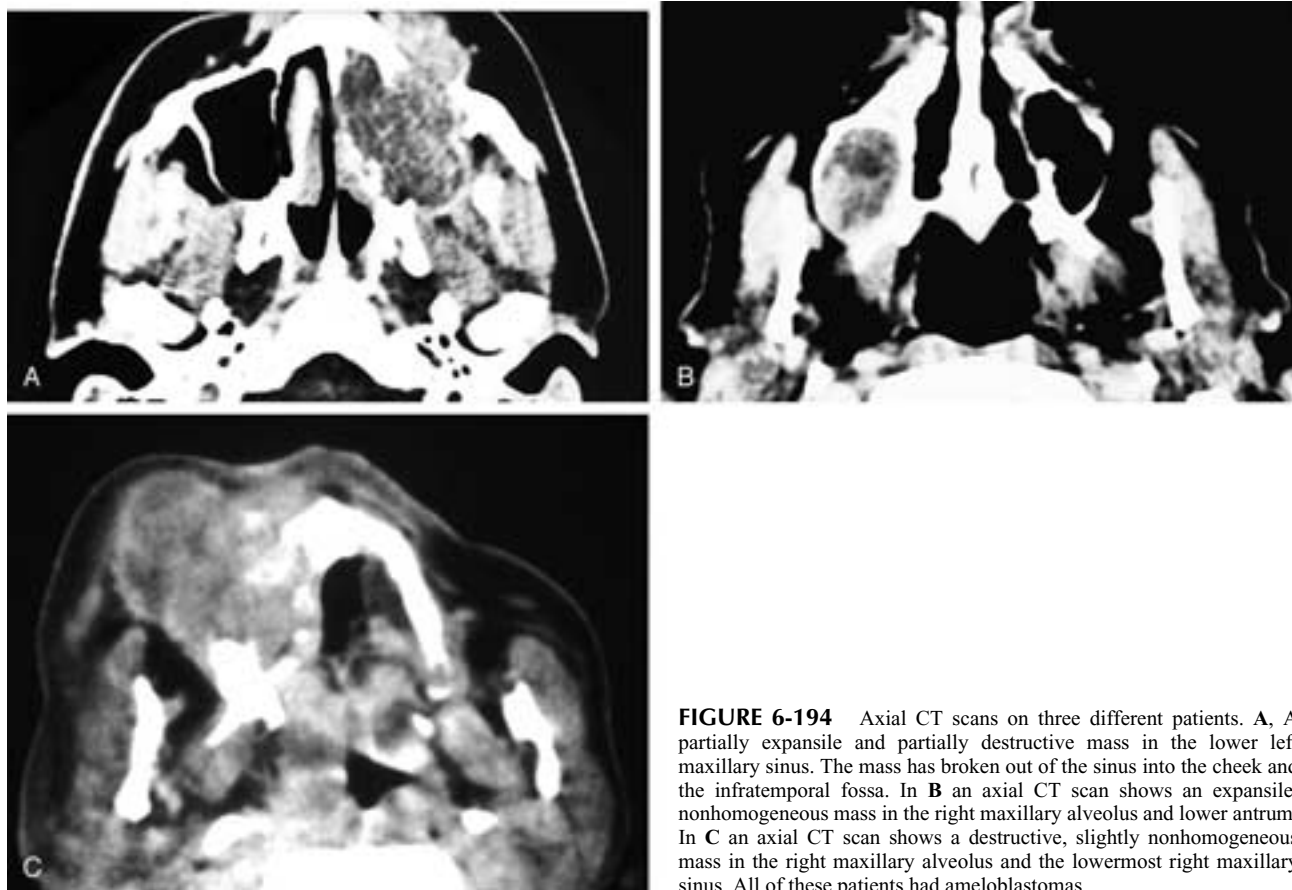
Axial CT scans on three different patients. A, A partially expansile and partially destructive mass in the lower left maxillary sinus. The mass has broken out of the sinus into the cheek and the infratemporal fossa. In B an axial CT scan shows an expansile, nonhomogeneous mass in the right maxillary alveolus and lower antrum. In C an axial CT scan shows a destructive, slightly nonhomogeneous mass in the right maxillary alveolus and the lowermost right maxillary sinus. All of these patients had ameloblastomas.
